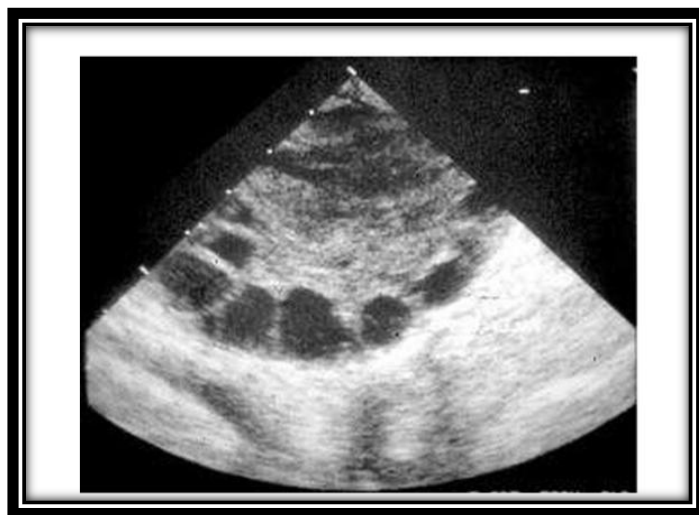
Ultrasound picture of a polycystic ovary
